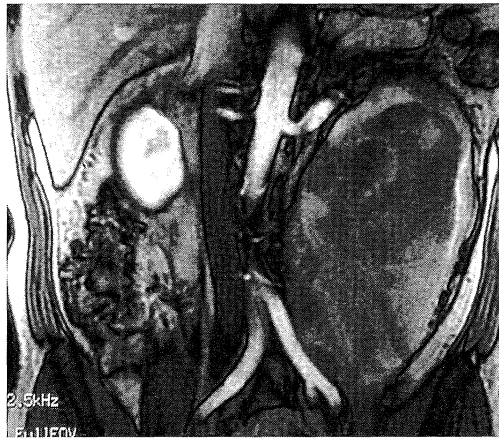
MR imaging at the second admission.
